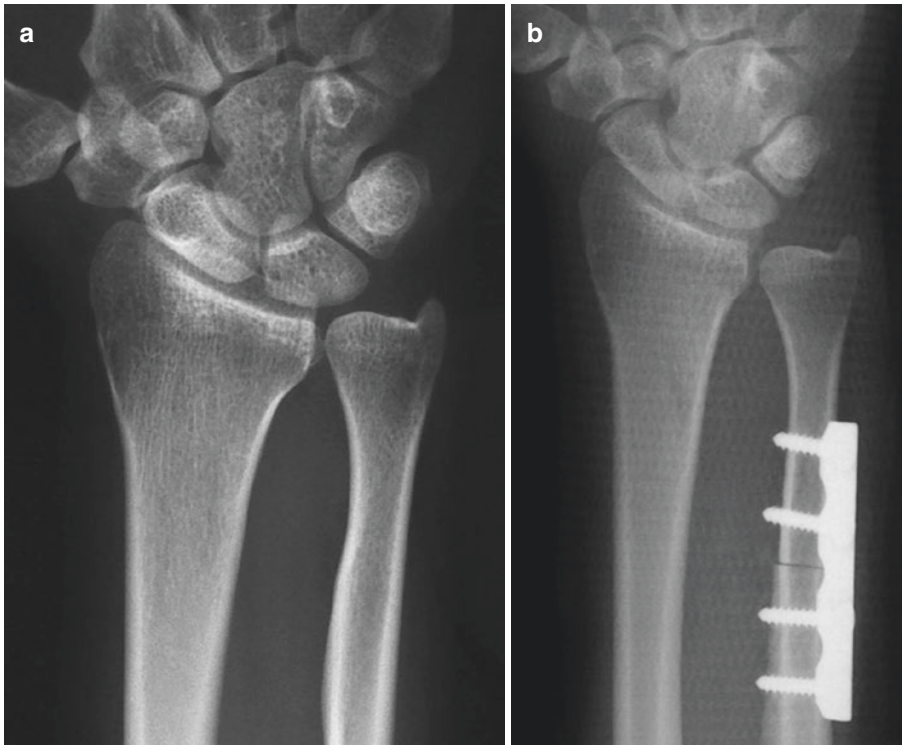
(a) Pre-operative PA radiograph indicating positive ulnar variance. (b) postoperative PA radiograph after ulnar shortening
